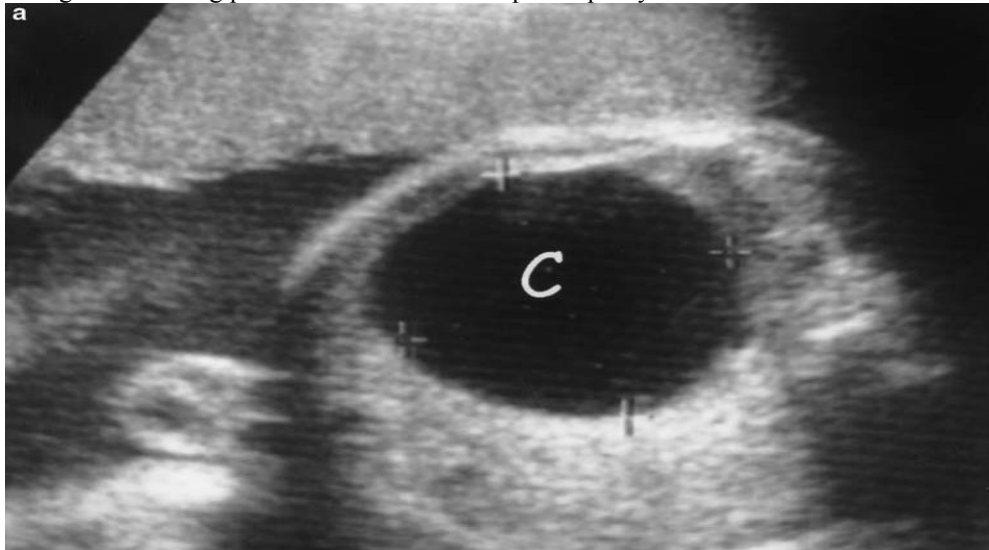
Antenatal ultrasound showing cystic lesion upper abdomen.
